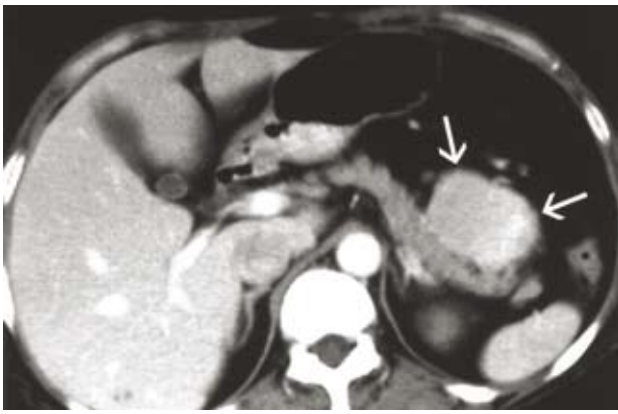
CT scan of the abdomen in a patient with CD showing heterogenous solid mass with no organ enlargement. At laparoscopy the tumor was found to arise from the mesenteric lymph nodes.
